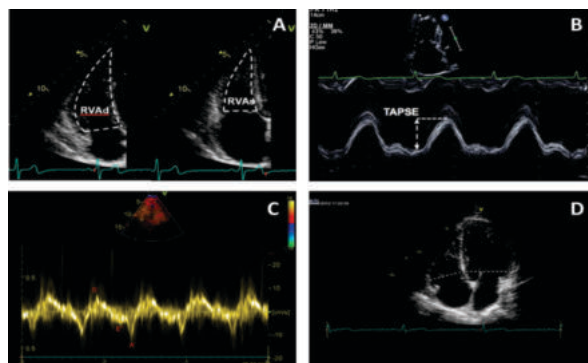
A. RVAd- RV area (in end diastole), RVAs- RV area (in end systole) ; B. Dotted vertical line adjacent to slope measured after placing M-mode in direction of lateral tricuspid valve ; C. Measurement of RV S', E', A' after placing tissue doppler and pulse wave over tricuspid valve; D. view depicting RV and LV base diameter in end diastole
